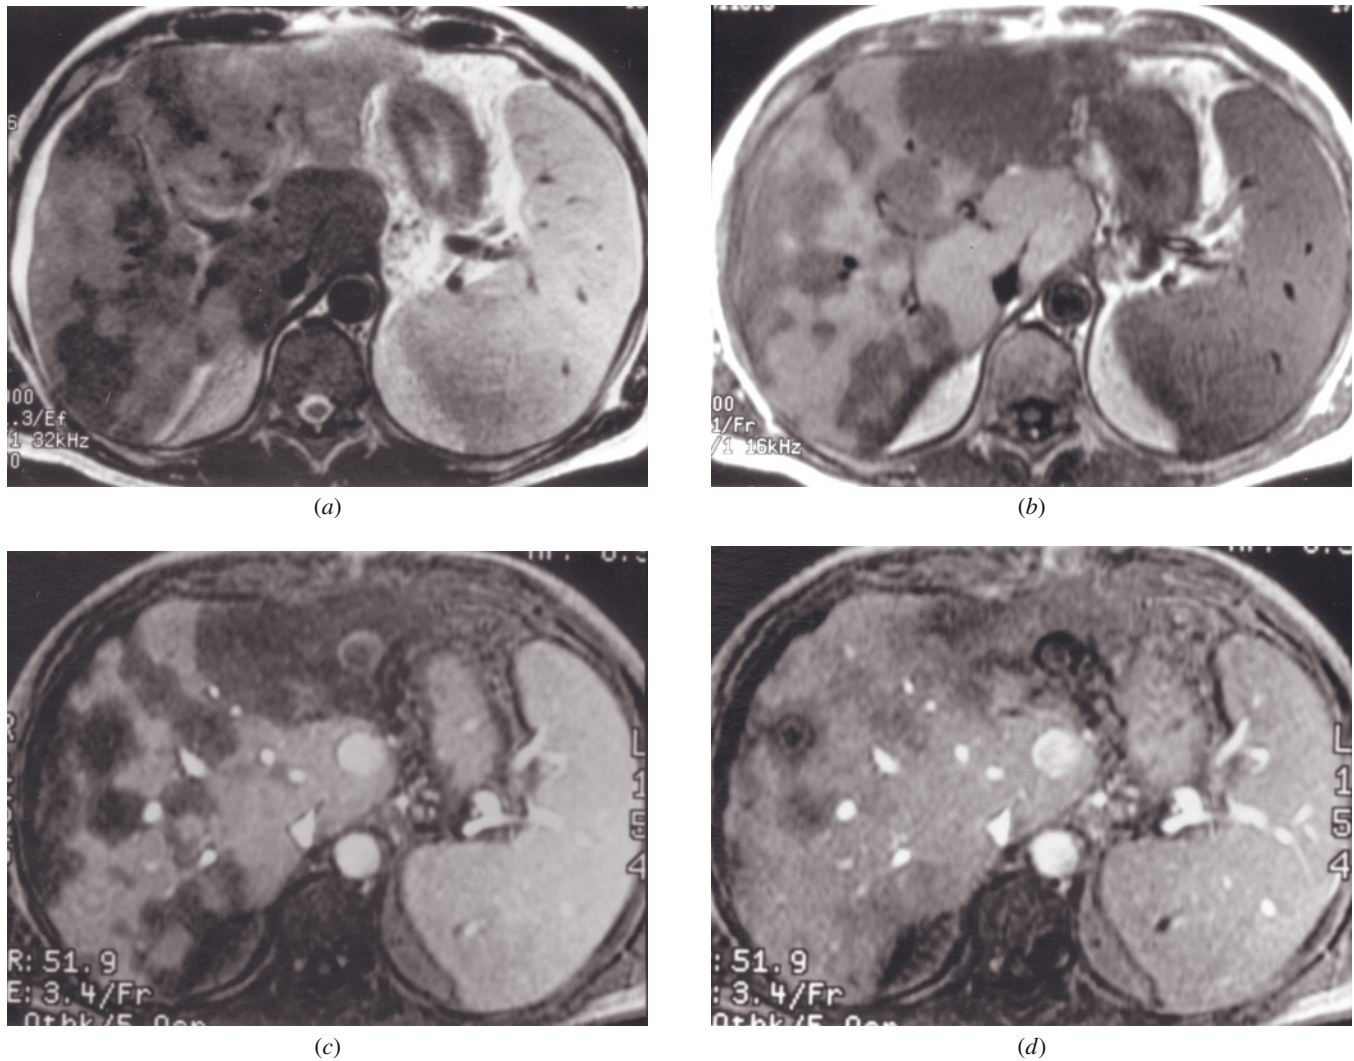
Angiotropic intravascular lymphoma. T2-weighted ETSE (a), SGE (b), and immediate (c) and 90-s (d) postgadolinium SGE images. There is an irregular geographic pattern of liver involvement that represents angiotropic intravascular lymphoma. The vascular involvement causes moderately high signal on T2 (a), moderately low signal on T1 (b), and negligible early enhancement (c) with delayed enhancement (d) (Courtesy of Evan Siegelman, M. D., Dept. Radiology, Hospital of the University of Pennsylvania.)
